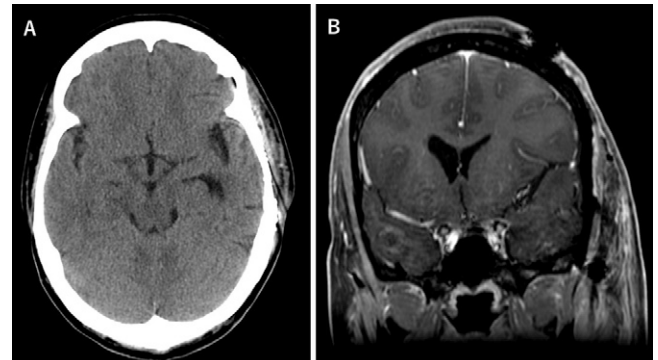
A: Postoperative axial CT scan showed improvement of the brain shift. B: Coronal postcontrast T1-weighted MRI sequence showed no residual tumor.
